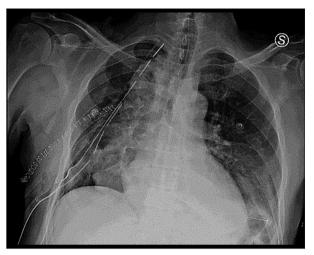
Day 3 postoperative chest X-ray after lvor-Lewi esophagectomy, showing no sign of consolidation or effusion before apical drain removal.
